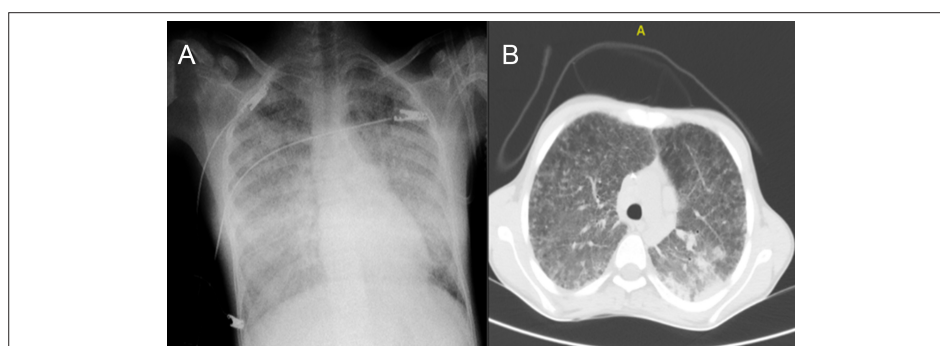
Radiologic evaluation: (A) Posteroanterior chest x-ray demonstrating bilateral pulmonary infiltrations. (B) Computerized tomography scan of the chest showed ground-glass opacities and interlobular septal thickening in both lung fields.
